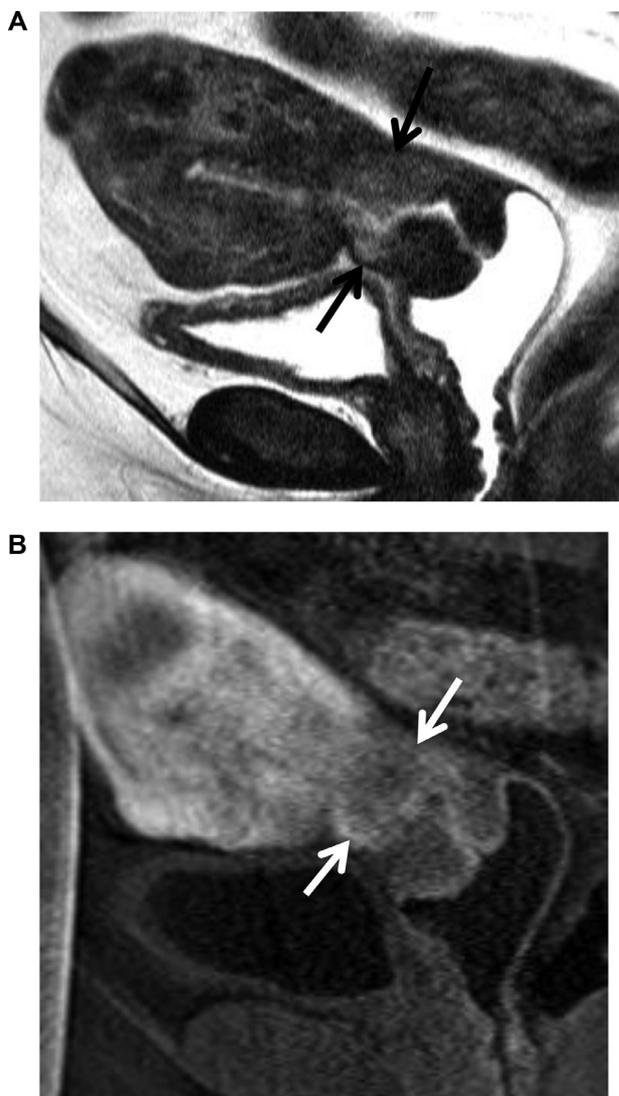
77-year-old female with endometrial cancer. (A) Sagittal T2-weighted image, and sagittal postcontrast T1-weighted image (B) images show an ill-defined enhancing mass in the lower uterine segment measuring approximately 3.2×3.1 cm (arrows) with more than 50% of myometrial invasion. It invades the superior cervix but there is no extension beyond the uterus indicating stage II disease.
